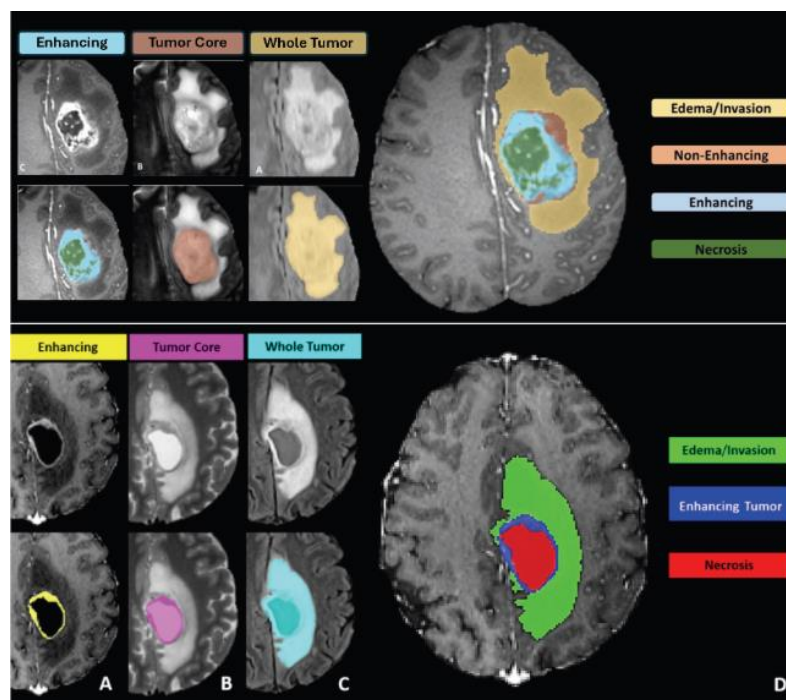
Visualization of glioma subregion segmentation on multi-modal brain MRI, highlighting enhancing tumor, tumor core, edema/invasion, and necrotic regions.
